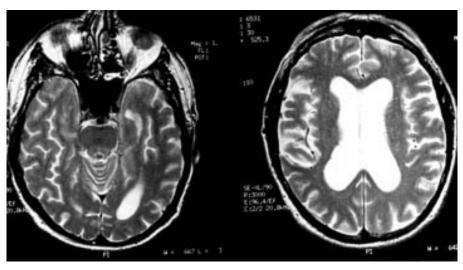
MRI brain scan performed 11 days after onset of symptoms. Axial T₂ weighted images show mild atrophy, but no intracerebral lesions.
